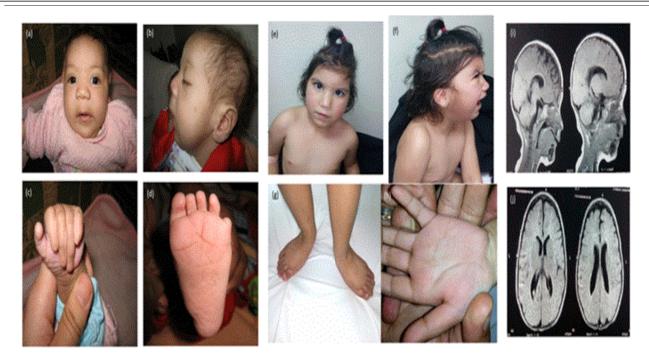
Patient 1: Squint, bilateral epicanthic folds, blue sclera, depressed nasal root, broad bulbous nose, long flat philtrum, thin lips, microretrognathia, bilateral malformed posteriorly rotated low set ears with absent tragus and prominent antitragus (a, b). Hands and feet showed complete absence of nails (total anonychia), hypoplastic 5th. toe with bilateral deep plantar creases (c, d). Patient 2: Narrowing forehead, sparse hair, bilateral epicanthic folds, hypertelorism, squint, full cheeks, depressed nasal bridge, bulbous broad nose, long flat philtrum, retromicrognathia, bilateral low set small malformed ears with abnormal thick folding, short neck, wide space nipples (e, f). incomplete simian crease on left hand, talipes valgus, bilateral syndactyly between 3rd and 4th toes, and bilateral flat foot were noticed (g, h). MRI brain showed atrophic brain changes and hypogenesis corpus callosum (i, j).
